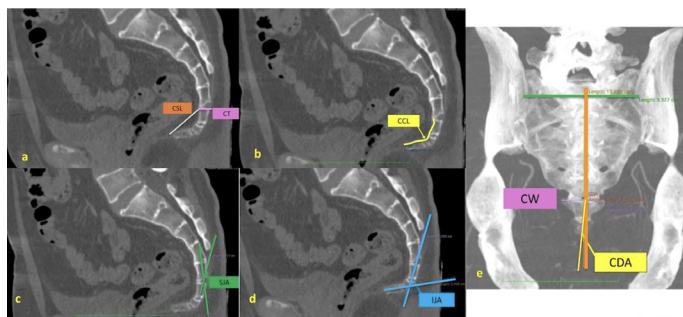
On Sagittal plane a) CSL: coccyx straight length, CT: coccyx thickness; b) CCL: coccyx curvature length; c) SJA: sacrococcygeal joint angle; d) IJA: intercoccygeal joint angle; On Coronal plane e) CW: coccyx width, CDA: coccyx deviation angle
